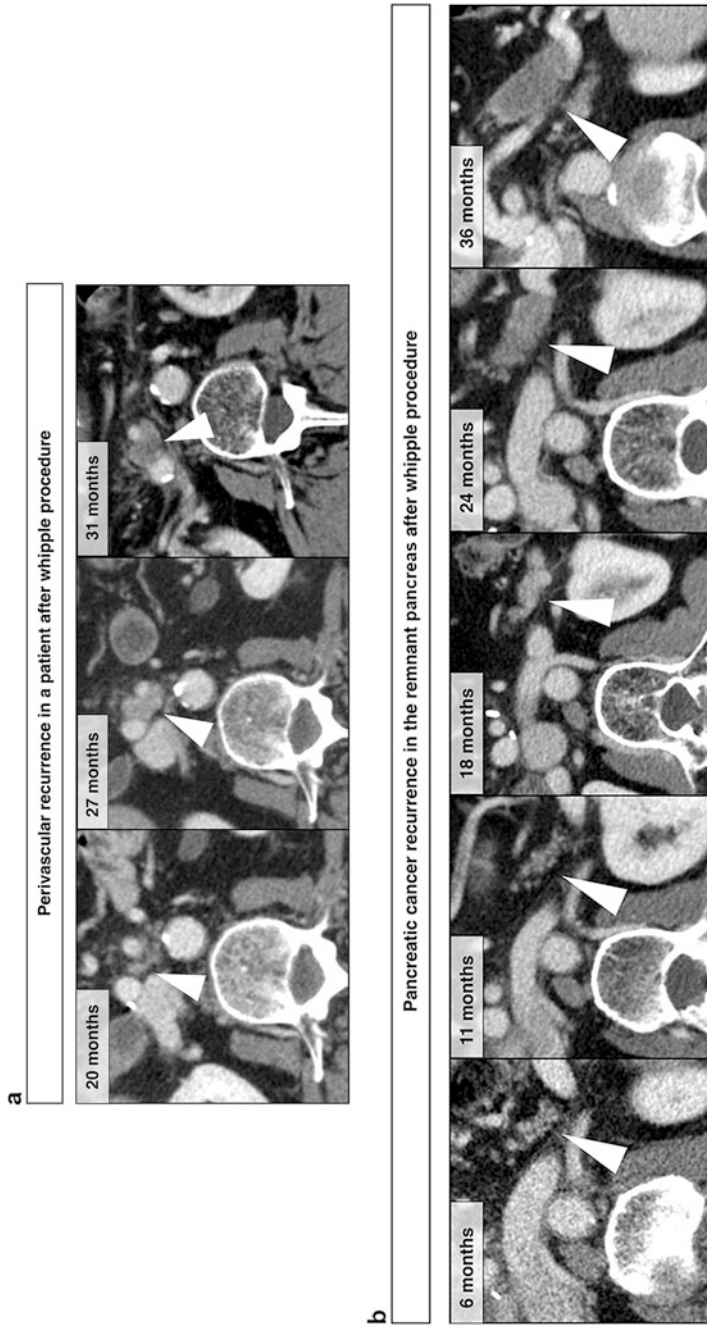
Typical findings of local recurrence in sequential CT scans for surveillance after resection for pancreatic adenocarcinoma. (a) Perivascular recurrence at different time points after pancreatoduodenectomy for pT3N1R1 ductal adenocarcinoma in a 64-year-old patient. Unsuspecting findings at 20 months. At 27 months increase of dense tissue between the superior mesenteric artery and vein with further increase and hypodense changes after 31 months. The patient underwent successful re-resection with intraoperative radiation therapy (IORT). (b) Local tumor recurrence involving the pancreatic remnant after pancreatoduodenectomy for pT3N1R1 ductal adenocarcinoma. Unsuspecting findings until 18 months after resection. Hypodens changes in the pancreatic remnant at 24 months with increase after 36 months. The patient underwent re-resection with completion pancreatotomy and adrenalectomy
